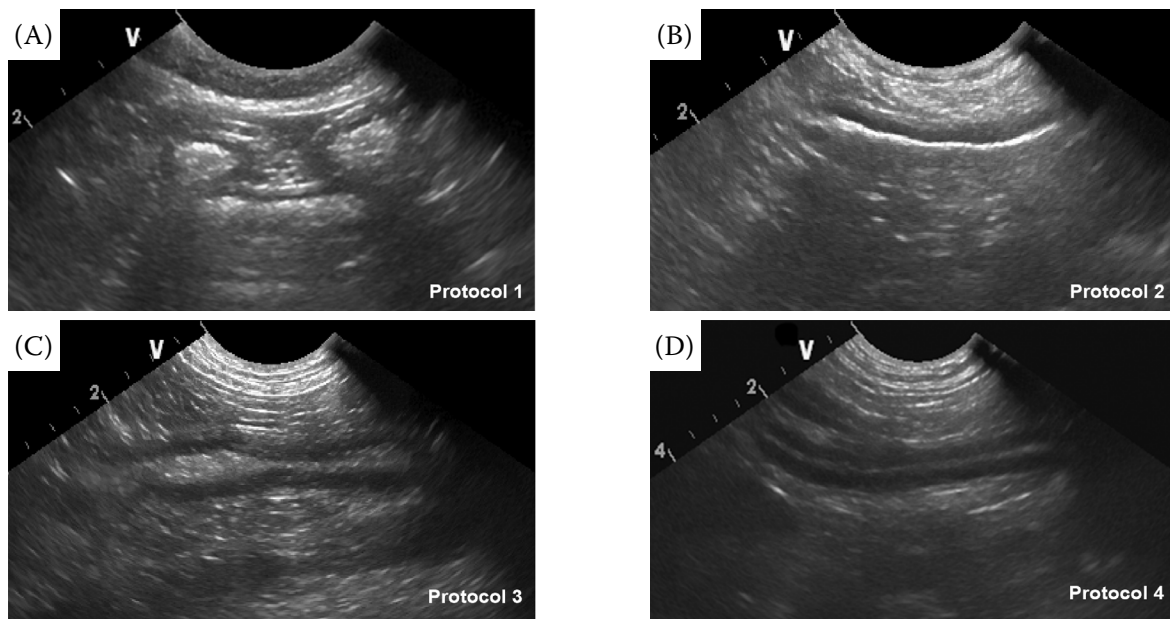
Ultrasonographic (USG) images of the jejunum
